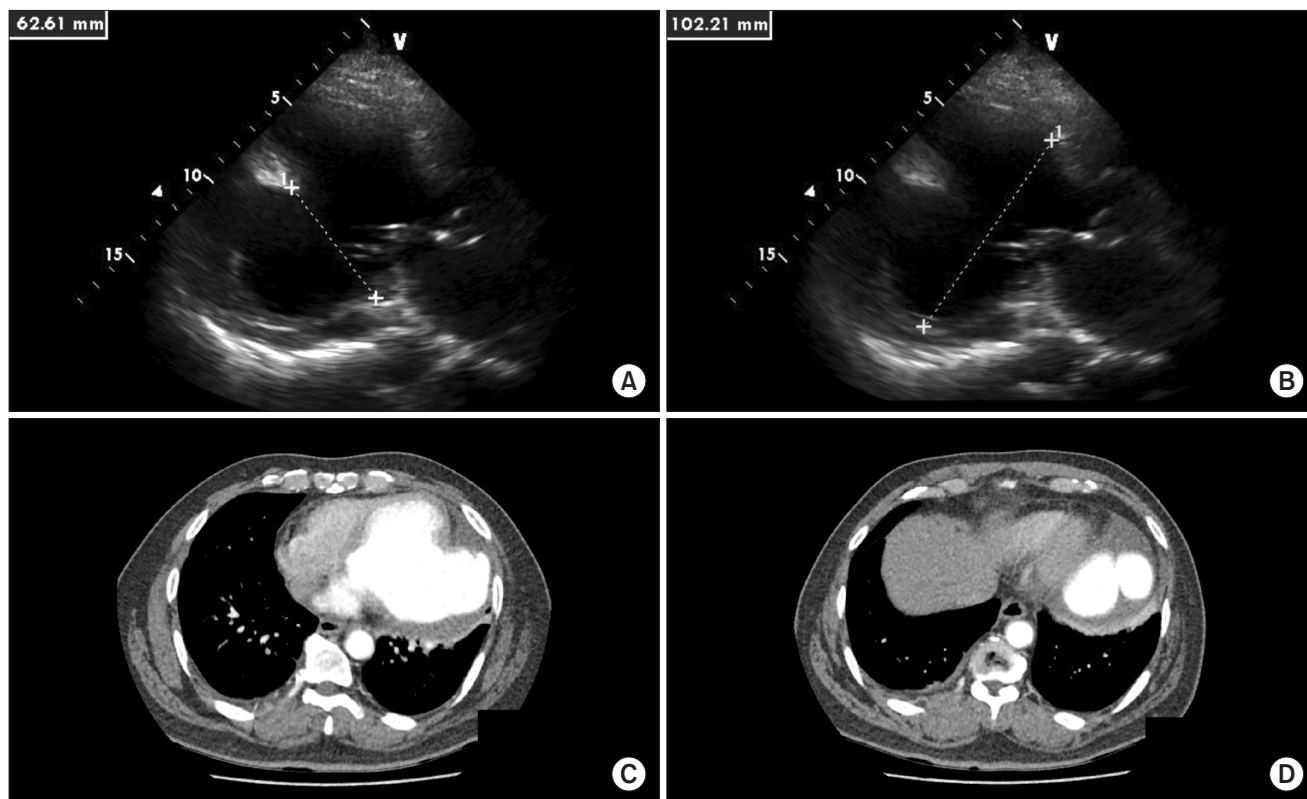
Transthoracic echocardiography shows the aneurysmal change in the LV posterior wall side with akinesia of the basal to mid posterior and lateral wall. LV systolic and diastolic dimensions were (A) 62.61 mm and (B) 102.2 mm, respectively. (C) and (D) Chest CT aortography. (C) A large (7 × 7 cm) aneurysm in the LV lateral wall. The base of the aneurysm had a thick wall and showed a contracting shape. (D) The apex had a thin wall, bulged in a "snowman" shape and dilated in the contraction phase.
